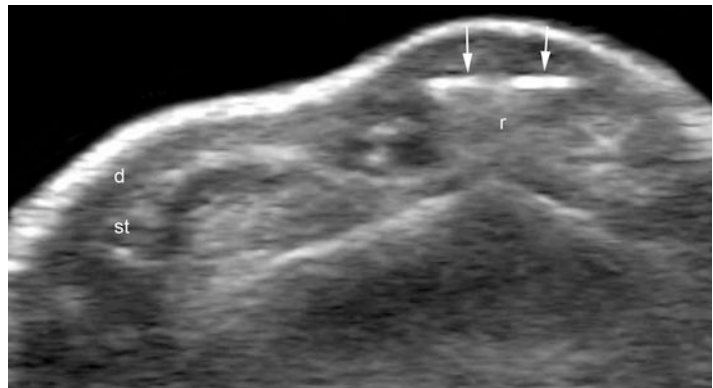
Foreign body. Grayscale ultrasound (transverse view, dorsum of the right index finger) shows two hyperechoic linear fragments (*arrows*) that correspond to glass fragments and elicit posterior reverberation artifact (*r*). Abbreviations: *d* dermis, *st* subcutaneous tissue
